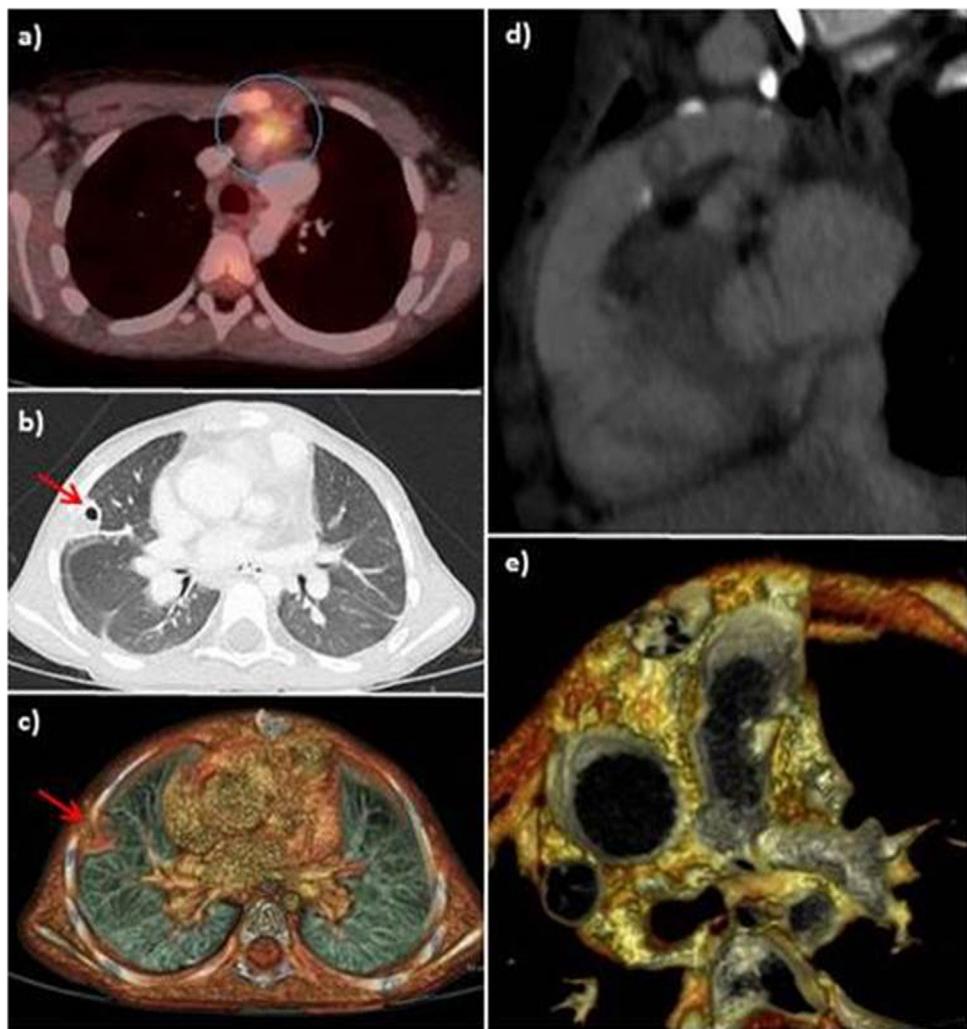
(a) Axial PET/CT image showing focal FDG uptake in the pulmonary graft (circle). (b) Chest CT, lung window. (c) 3D volume rendering image showing a peripheral cavitary lesion (red arrow) in the upper right lobe. (d) and (e) The retrospective interpretation of the CT scan revealed a nodular lesion suggestive of a thrombus/vegetation in the lumen of the pulmonary conduit.
